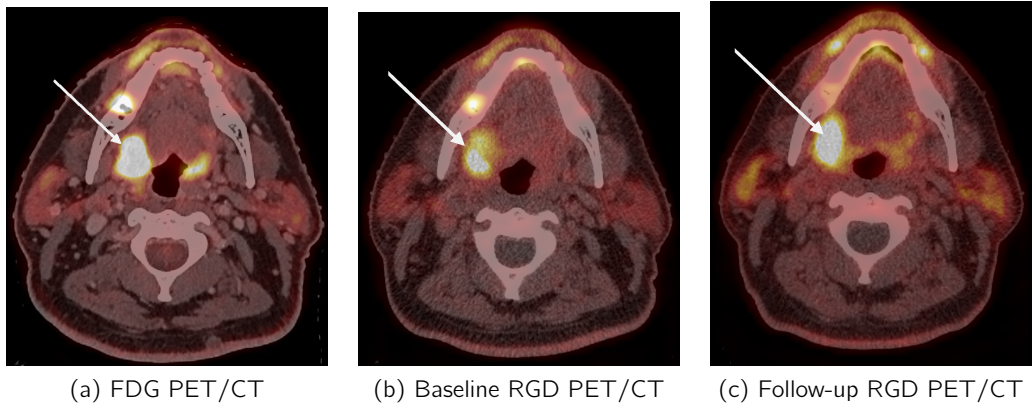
The tumour in the right tonsil loge on the three different PET/CTs
